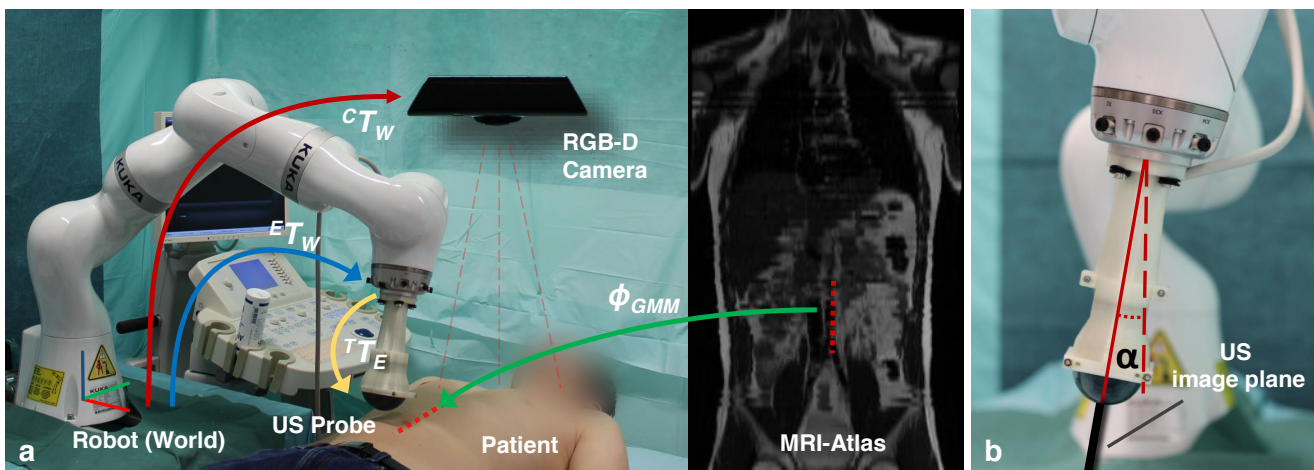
a) System setup showing the robot, the US transducer mounted to its end-effector, the RGB-D camera on the ceiling, the patient, a coronal slice of the MRI atlas, and all required transformations, including the camera-to-robot (${}^C T_W$) and extrinsic US probe calibrations (${}^T T_E$). The red-dotted line indicates the scan trajectory. b) Close-up of the US transducer, showing the US imaging plane (thick black line) and the out-of-plane rotation angle α .
